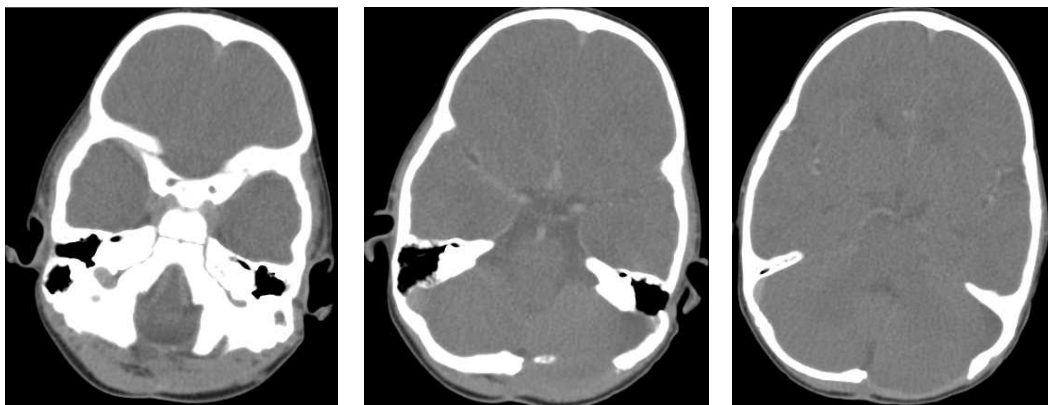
Preoperative images: brain CT and brain MRI of the; cerebellopontine angle subdural empyema
